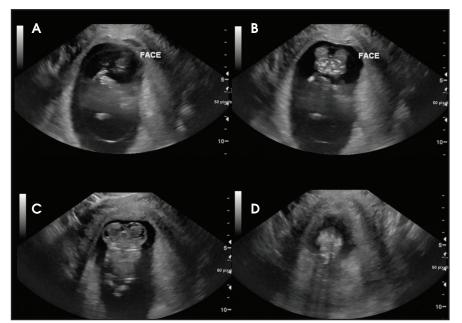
Coronal gray scale transvaginal ultrasound scanning anterior to posterior demonstrates a fetus with (A) two upper extremities, (B) two maxillofacial structures fused at midline, (C) two heads fused at midline, a single thorax/abdomen with two lower extremities and (D) partial duplication of the spine.
